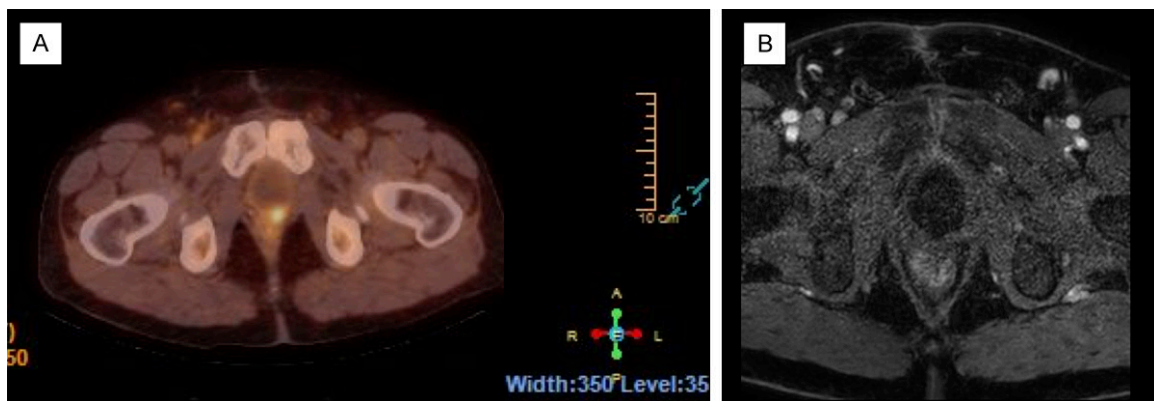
PET/CT and MRI examination of a 67 years old patient after radical prostatectomy one year ago, current PSA level-0.48 ng/ml. ^{18}F -PSMA-1007 accumulation in the left side of the prostate bed (A). This lesion can not be seen on the corresponding DCE-MRI series (B).
